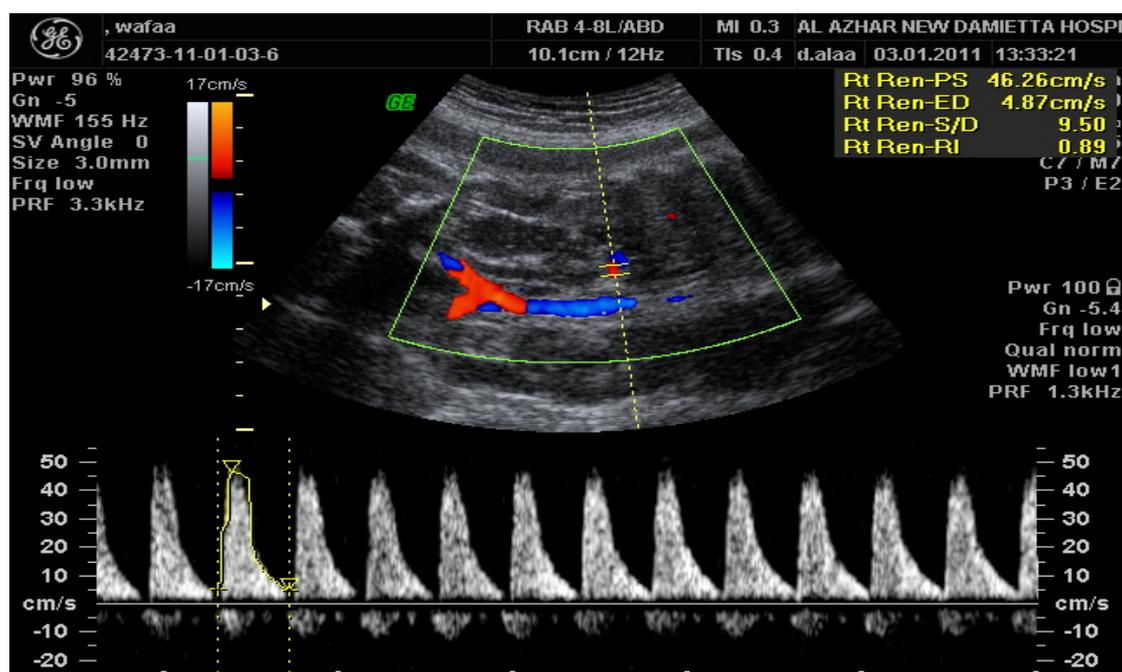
Fetal Renal artery Doppler velocimetry at 35weeks
